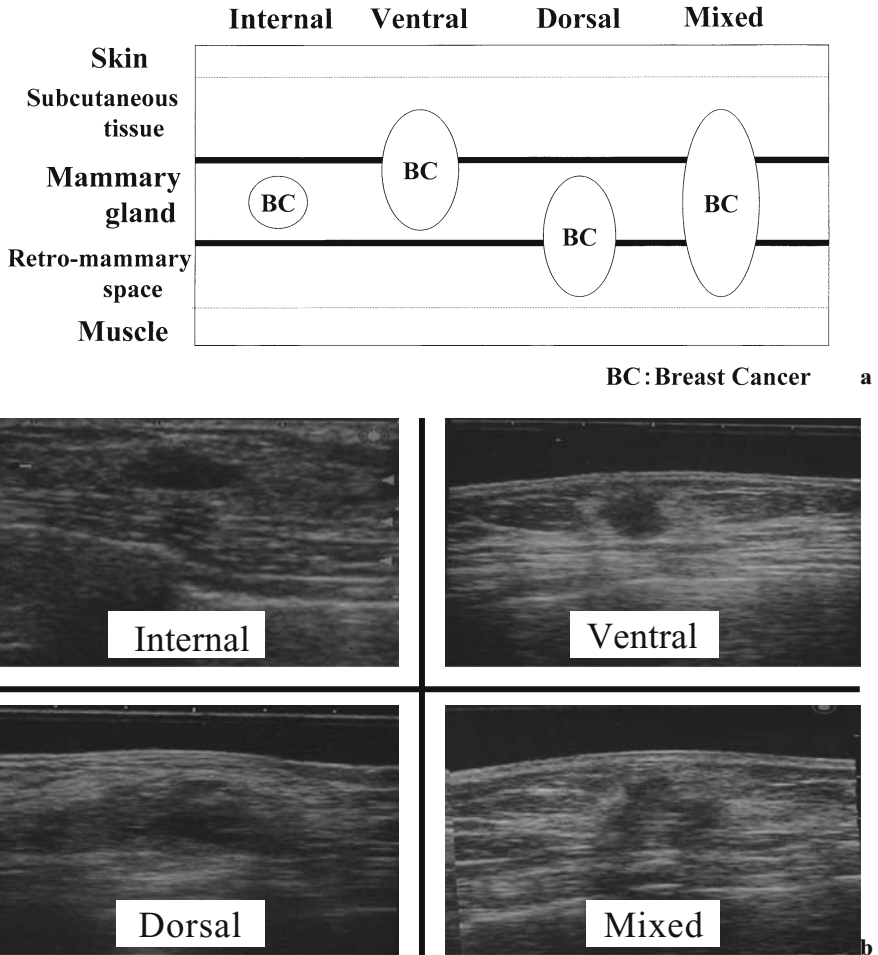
The four categories of breast cancer by ultrasonography (US)
